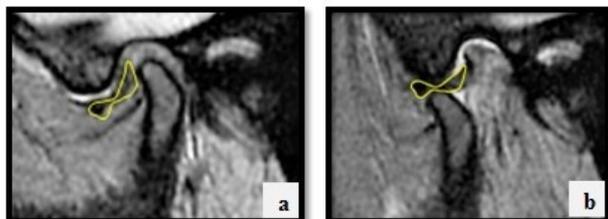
Oblique sagittal PD MRI sequence showing: a) anterior disc displacement in closed mouth position and b) in open mouth position where the articular disc is reduced confirming DDr. (articular disc outlined in yellow).
